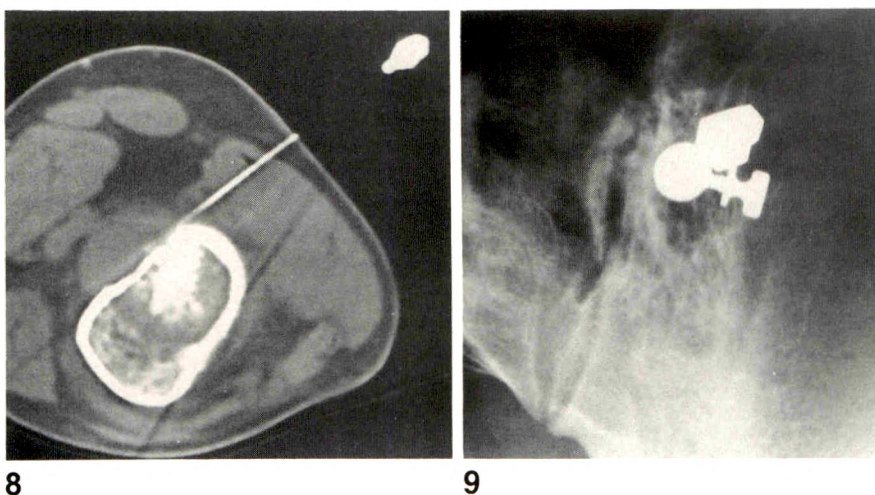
CT guidance is used for biopsy of nonmineralized soft-tissue component of this osteosarcoma. In this case, soft-tissue component was thought to represent highest-grade tissue. If it is possible to avoid cortical biopsy, risk of pathologic fracture is reduced.
